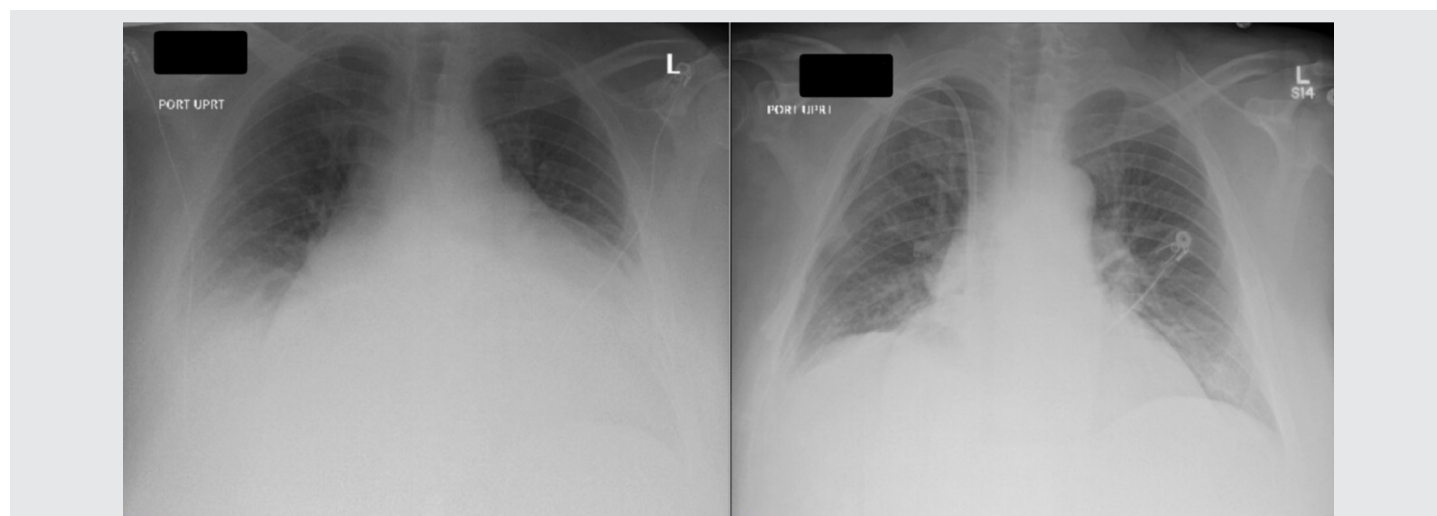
X-ray on admission and after pericardiocentesis.
